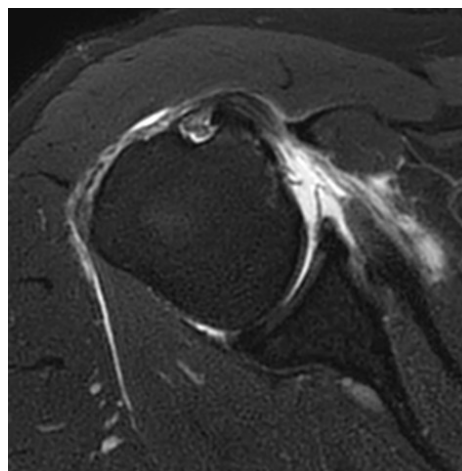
Oblique sagittal and axial fat-suppressed PD-weighted MRI scan. Subscapularis full-thickness tear. Provided by the authors.
